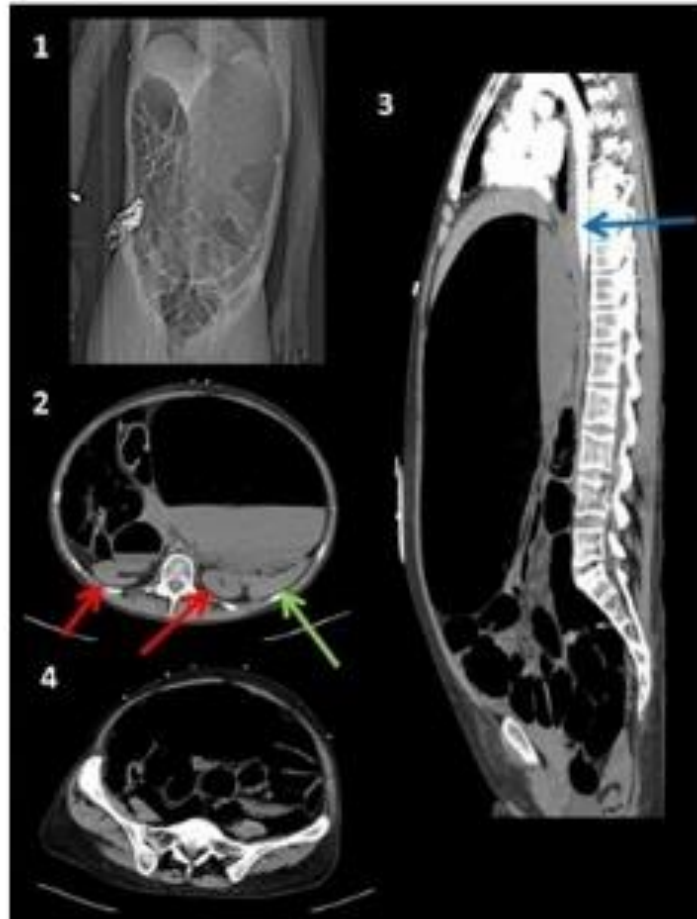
CT thoracoabdominal scout view shows a massive gastric dilatation. Fig. 2. Axial CT scan reveals the gastric dilatation with abundant content and the displacement of the kidneys (red arrows) and the spleen (green arrow). Note that these organs are not enhanced and the absence of opacified aorta and flattened IVC. Fig. 3. Sagittal reconstruction shows how the aorta is narrowed and is not opacified below T-11. Fig. 4. Dilatation of small bowel loops.
